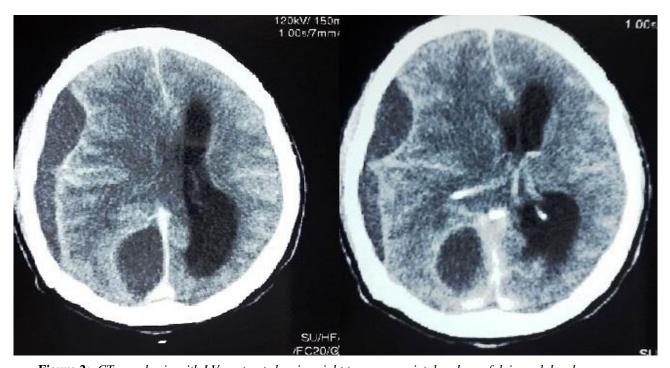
CT scan brain with I.V contrast showing right temporo parietal and parafalcine subdural empyema.
